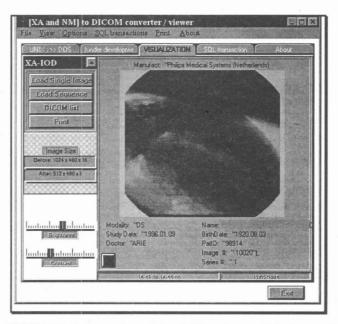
DICOM XA (x-ray angiography) or NM (nuclear medicine) converter/viewer GUI, showing the main menu window, options and a typical digital angiography study
